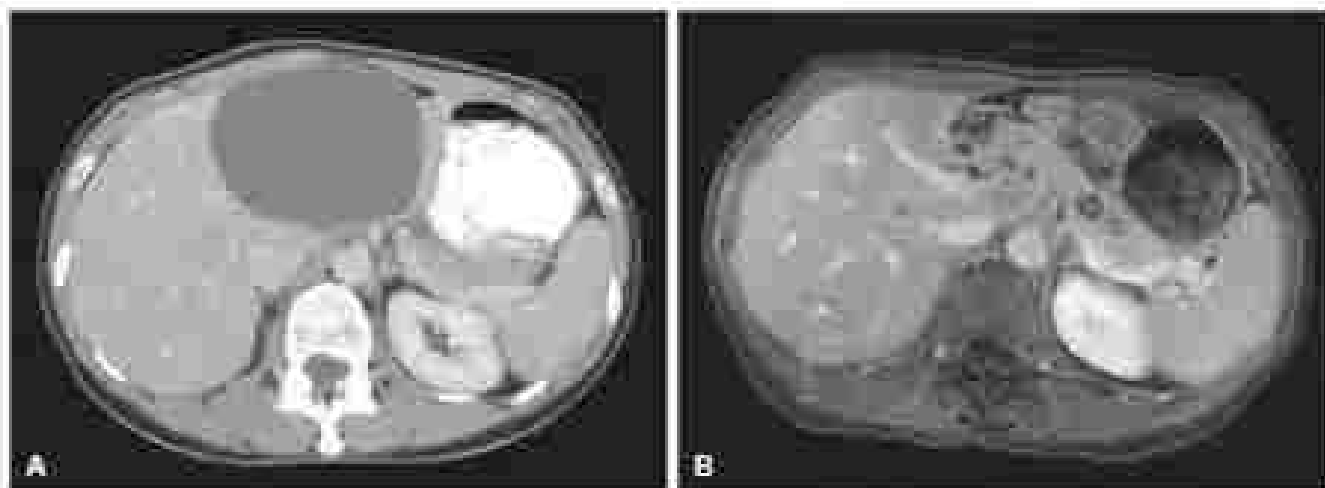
(A) Axial computed tomography demonstrating a simple liver cyst in the left lobe of the liver in a 54-year-old woman. (B) Axial T1-weighted magnetic resonance imaging after cyst aspiration shows minimal hypointense, minimal fluid in the cyst cavity.
